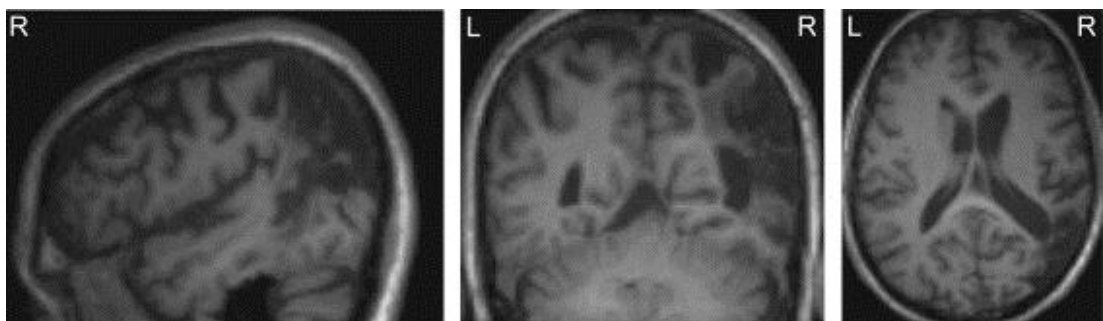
Right parietal lesion. T1-weighted structural MRI scan acquired during the first of two scanning sessions where the pre-existing right parietal lesion is clearly apparent.
